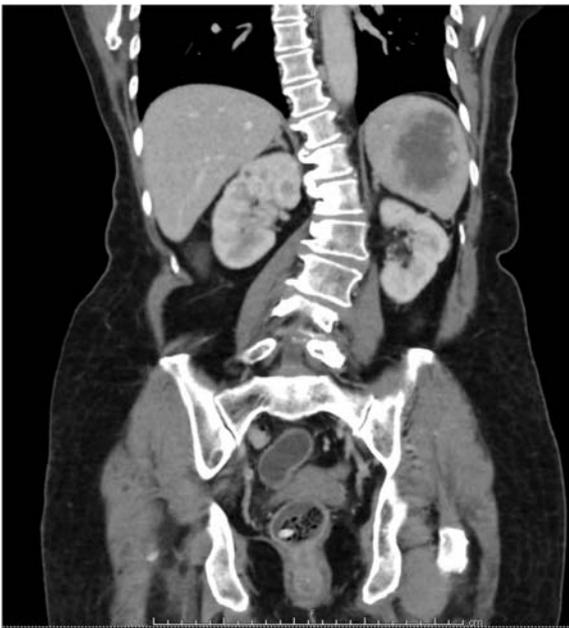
Splenic mass in coronal view of abdominal CT scan.
